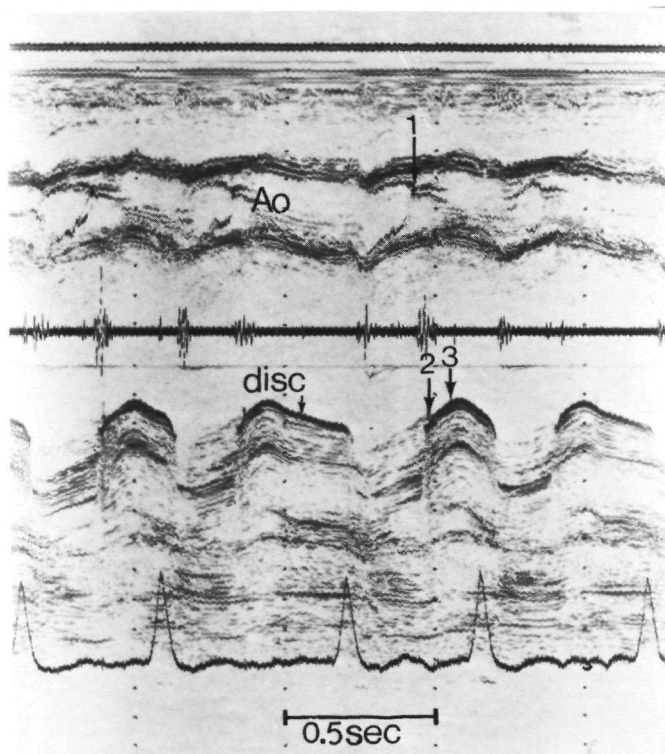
The simultaneous dual M-mode echocardiograms from the aortic valves (top trace) and the disc movement of the Björk-Shiley mitral valve prosthesis (bottom trace) in a patient with severe paravalvular regurgitation (case 39). The time interval from aortic valve closure (arrow 1) to mitral disc opening (arrow 2) was shortened (45 msec). Note the "hump" in early diastole (arrow 3). Paperspeed: 50 mm/sec.
